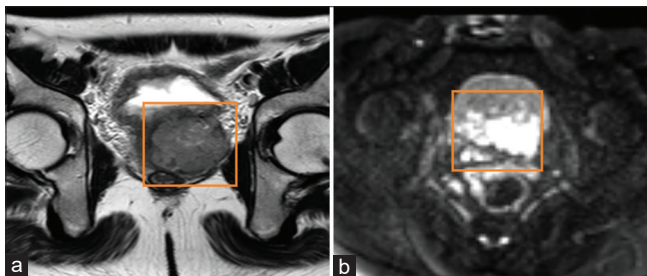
Magnetic resonance image: mass lesion beneath the urinary bladder and suspicious invasion of the seminal vesical. (a) T2 weighted and (b) diffuse-weighted imaging
